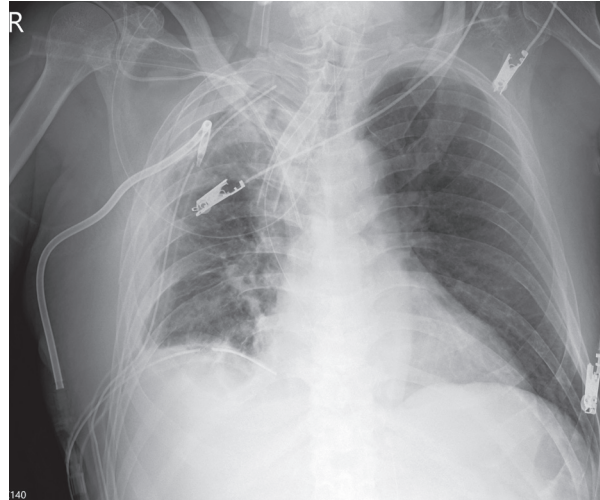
Plain film on POD 30 revealed that with the irrigation system, the right empyema thoracis and consolidation showed improvement.
